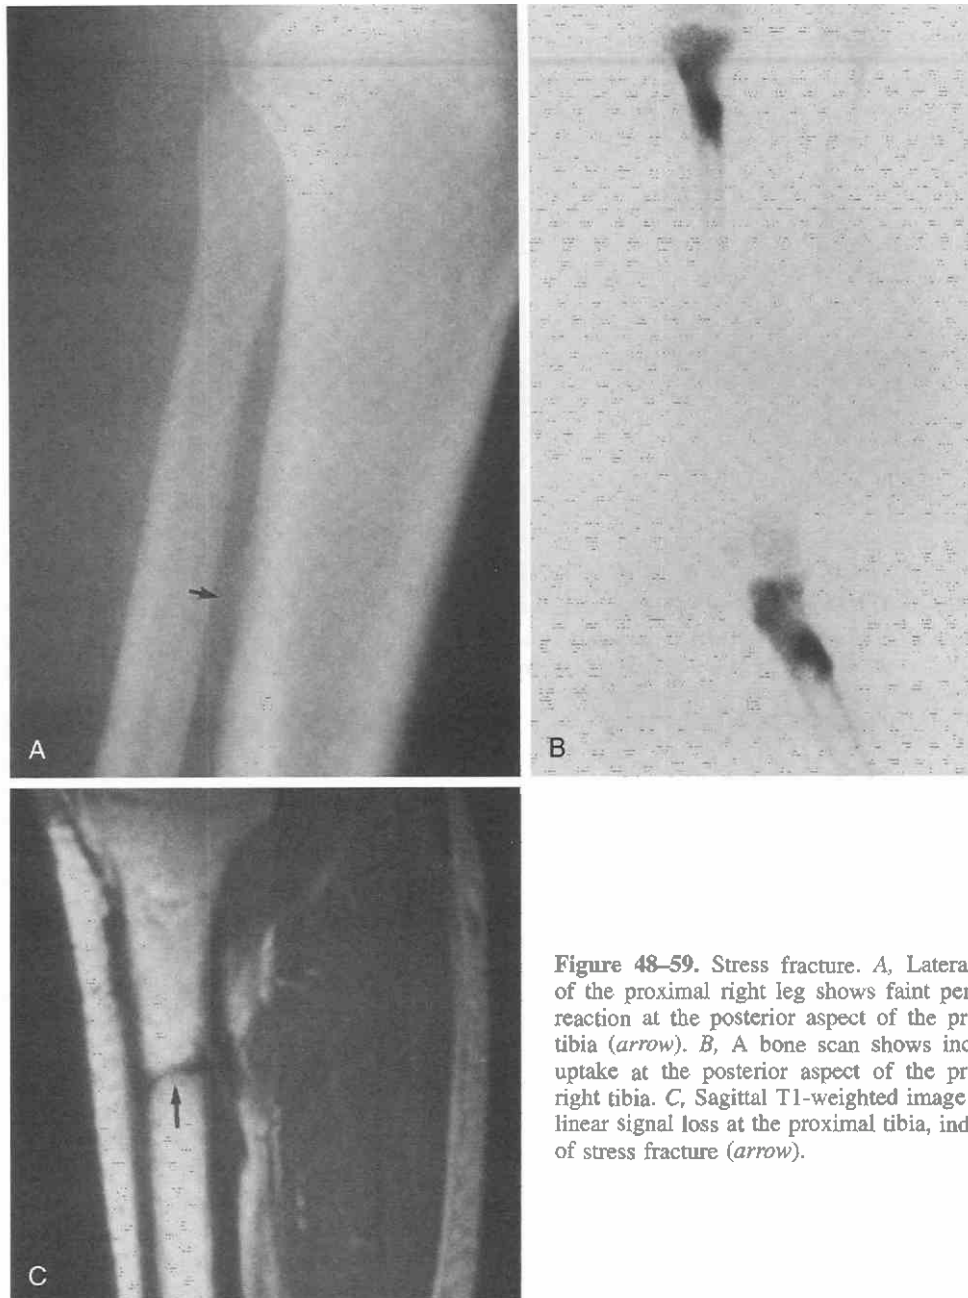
Stress fracture. *A*, Lateral view of the proximal right leg shows faint periosteal reaction at the posterior aspect of the proximal tibia (*arrow*). *B*, A bone scan shows increased uptake at the posterior aspect of the proximal right tibia. *C*, Sagittal T1-weighted image shows linear signal loss at the proximal tibia, indicative of stress fracture (*arrow*).
